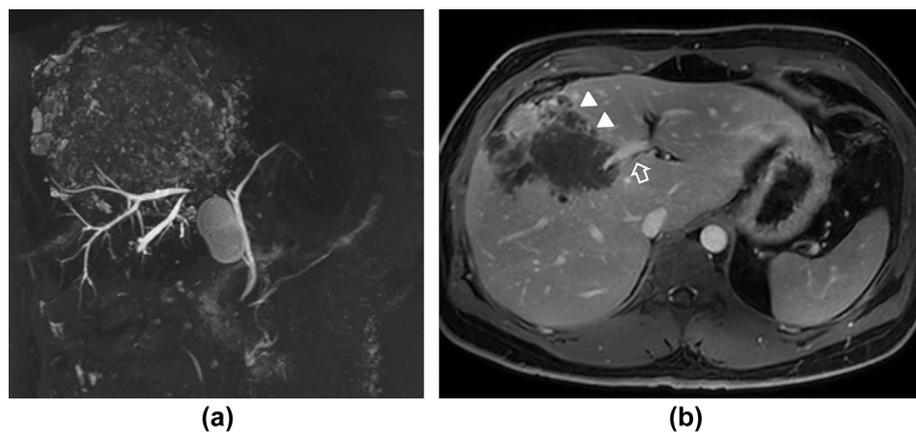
MRI as a useful tool for assessing the extent of (a) biliary and (b) vascular involvement. Both images have been obtained from the same patient demonstrating a large predominantly right hepatic cystic lesion with multiple small peripheral cystic areas. (a) On MRCP sequences, central occlusion of both right intrahepatic ductal systems is demonstrated with involvement of some of the anterior left segmental branches. (b) Following intravenous contrast medium administration, at the inferior margin of the lesion there is right main portal venous compromise (white arrow), with early extension into segment IV (two white triangles).
